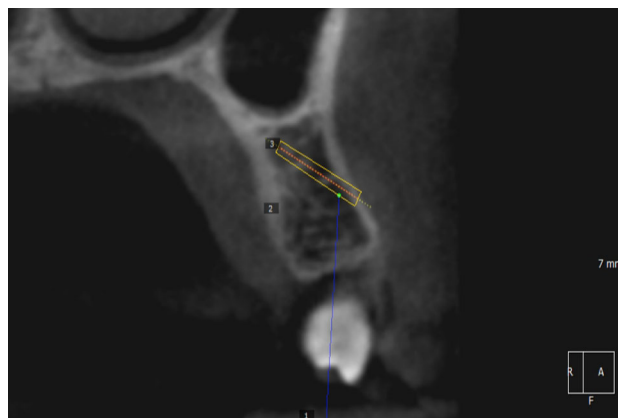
Microimplant angulation readout from cbct scan
